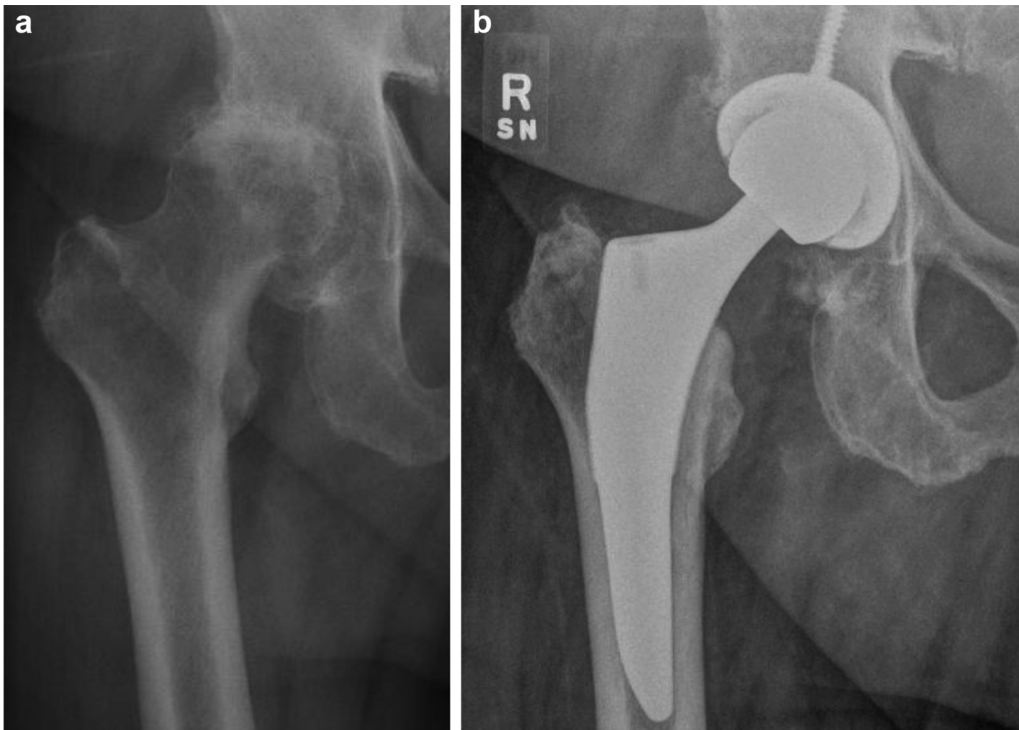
Eighty-five-year-old male who underwent revision knee surgery for several years of right knee pain but without relief. Right hip radiographs (a) revealed Grade 3 OA. Knee pain completely resolved after right THA (b).
